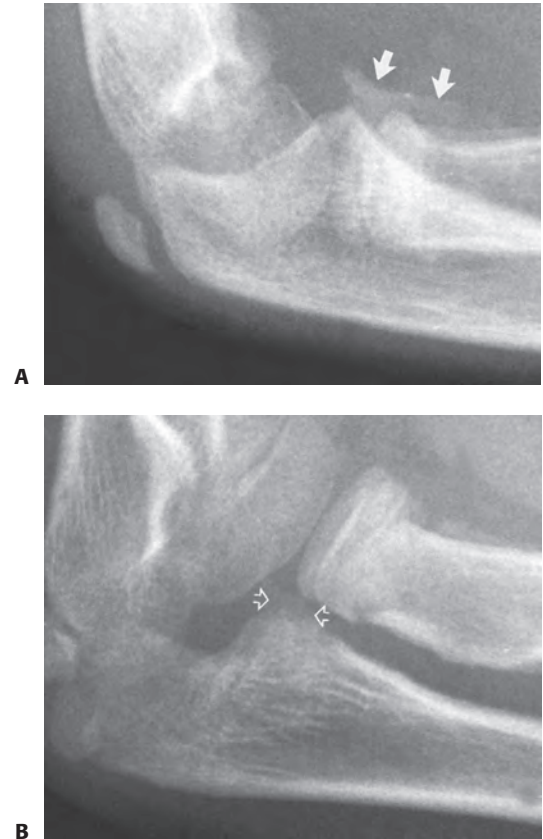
The radiocapitellar view. A: Radiographs of a 13-year-old female who sustained a radial neck fracture associated with an elbow dislocation. There is ectopic bone formation (*arrows*). In this view, it is difficult to tell the exact location of the ectopic bone. B: The radiocapitellar view separates the radial head from the coronoid process and shows that the ectopic bone is from the coronoid process (*arrows*) and not the radial neck.
